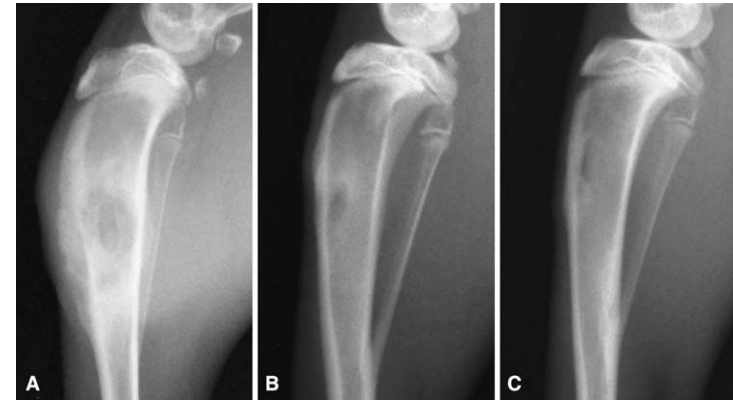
C (A) A radiograph taken 4 weeks after surgery shows a bone wax-treated tibia inoculated with *Staphylococcus aureus*. Clear signs of osteomyelitis can be seen, including bone lysis and periosteal reaction. Bone explants cultured in 5% TSB showed heavy growth of *Staphylococcus aureus*. (B) A representative radiograph taken 4
